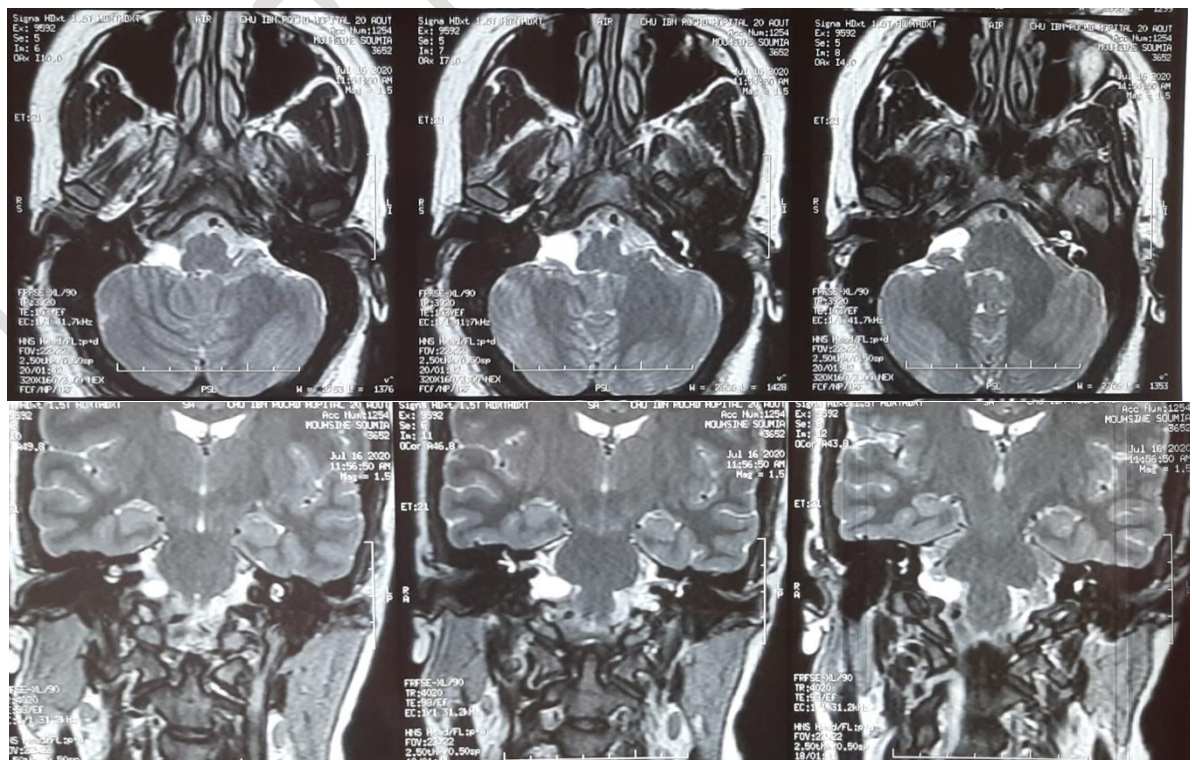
axial and coronal MRI slices of the ponto-cerebellar angle T2 sequence of our case
